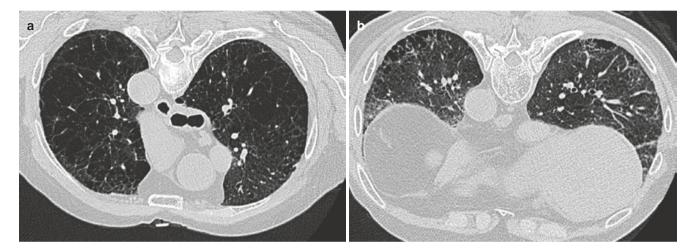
Paraseptal emphysema versus honeycombing. (a, b) Axial prone CT images show confluent emphysema in upper lungs and paraseptal emphysema in posterior lung bases. Note irregular cystic spaces with irregular walls not satisfying the definition of honeycombing
